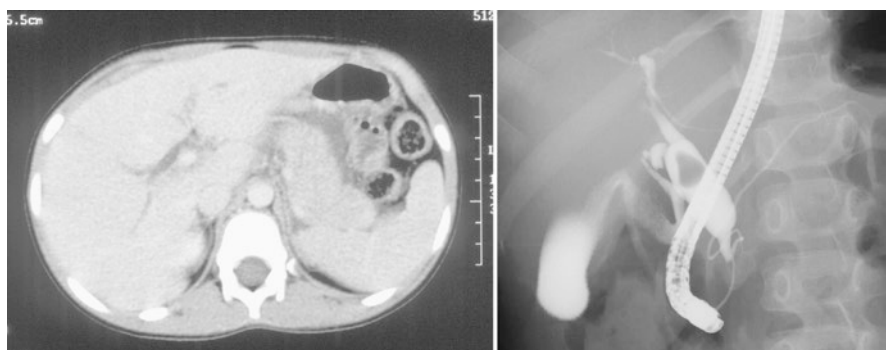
A rare case of true pancreatitis. A 6-year-old girl had acute abdominal pain and vomited several times. Serum levels of transaminase, amylase, and lipase were elevated. Computed tomography showed pancreatic enlargement and adjacent fluid collection (*left*). Six weeks later when symptoms subsided, endoscopic retrograde cholangiopancreatography showed a dilated common bile duct with pancreaticobiliary maljunction and a large filling defect in the dilated bile duct (*right*). After 2 weeks, the patient underwent surgery. Operative cholangiography showed the filling defect had disappeared, but many white fragments of protein plugs were found in the bile. Protein plugs are generally fragile. The plugs blocking the common channel usually flow out spontaneously before causing true pancreatitis, but in this case, plugs must have been more stubborn than usual
